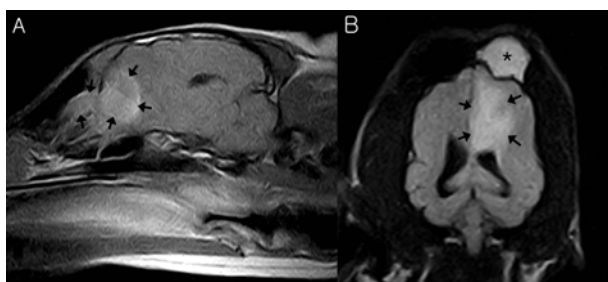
Magnetic resonance images of the brain. A: Post-contrast T1-weighted sagittal image reveals that the hyper-signal intense mass (arrow) in the left frontal lobe connected to the nasal septum and nasal cavity. B: Hyperintense lesions are detected in the left frontal sinus (asterisk) and frontal lobe (arrow) on post-contrast FLAIR dorsal image.
